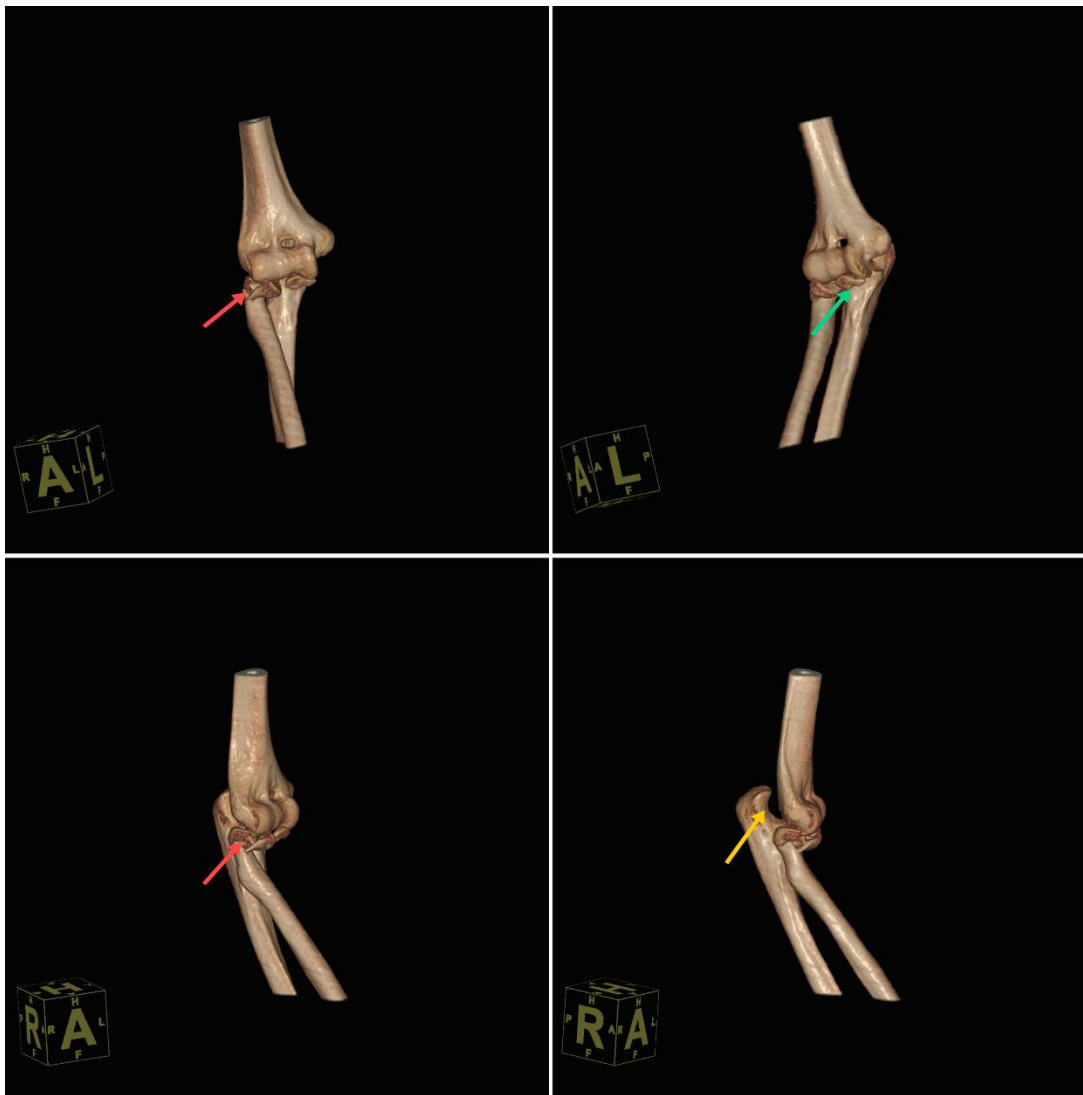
Preoperative CT+ 3D imaging of the elbow joint showing posterior dislocation of the right joint (yellow arrow), comminuted fracture of the right radial head type III (red arrow), and fracture of the right ulnar coronoid process type III (yellow dashed line).
